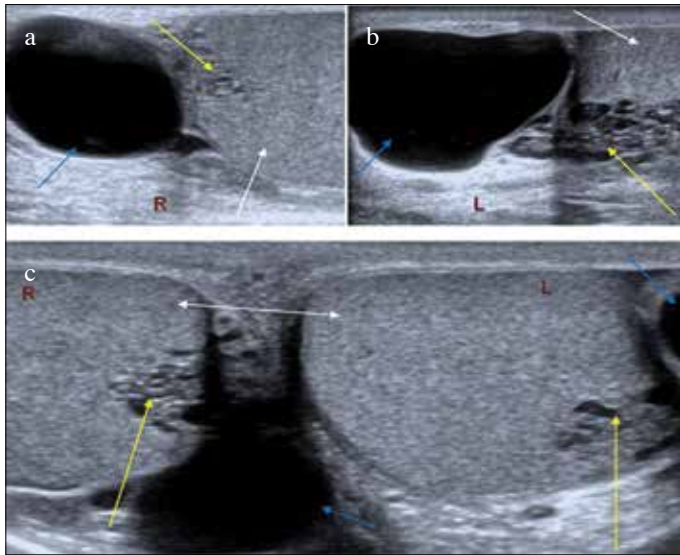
a-c. On scrotal ultrasonogram, normal testicular tissues (white arrows), epididymal cysts (blue arrows) and cystic dilations of rete testis (yellow arrows) are seen
